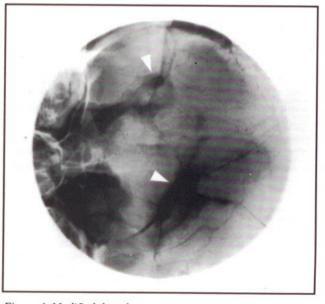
Modified dental x-ray generator projection of supraorbital area depicted in Fig. 3. In this view the two separate skull fractures located in the supra-orbital region are well visualised and the occupital features and anatomical structures have been selectively removed by magnification (arrows).
